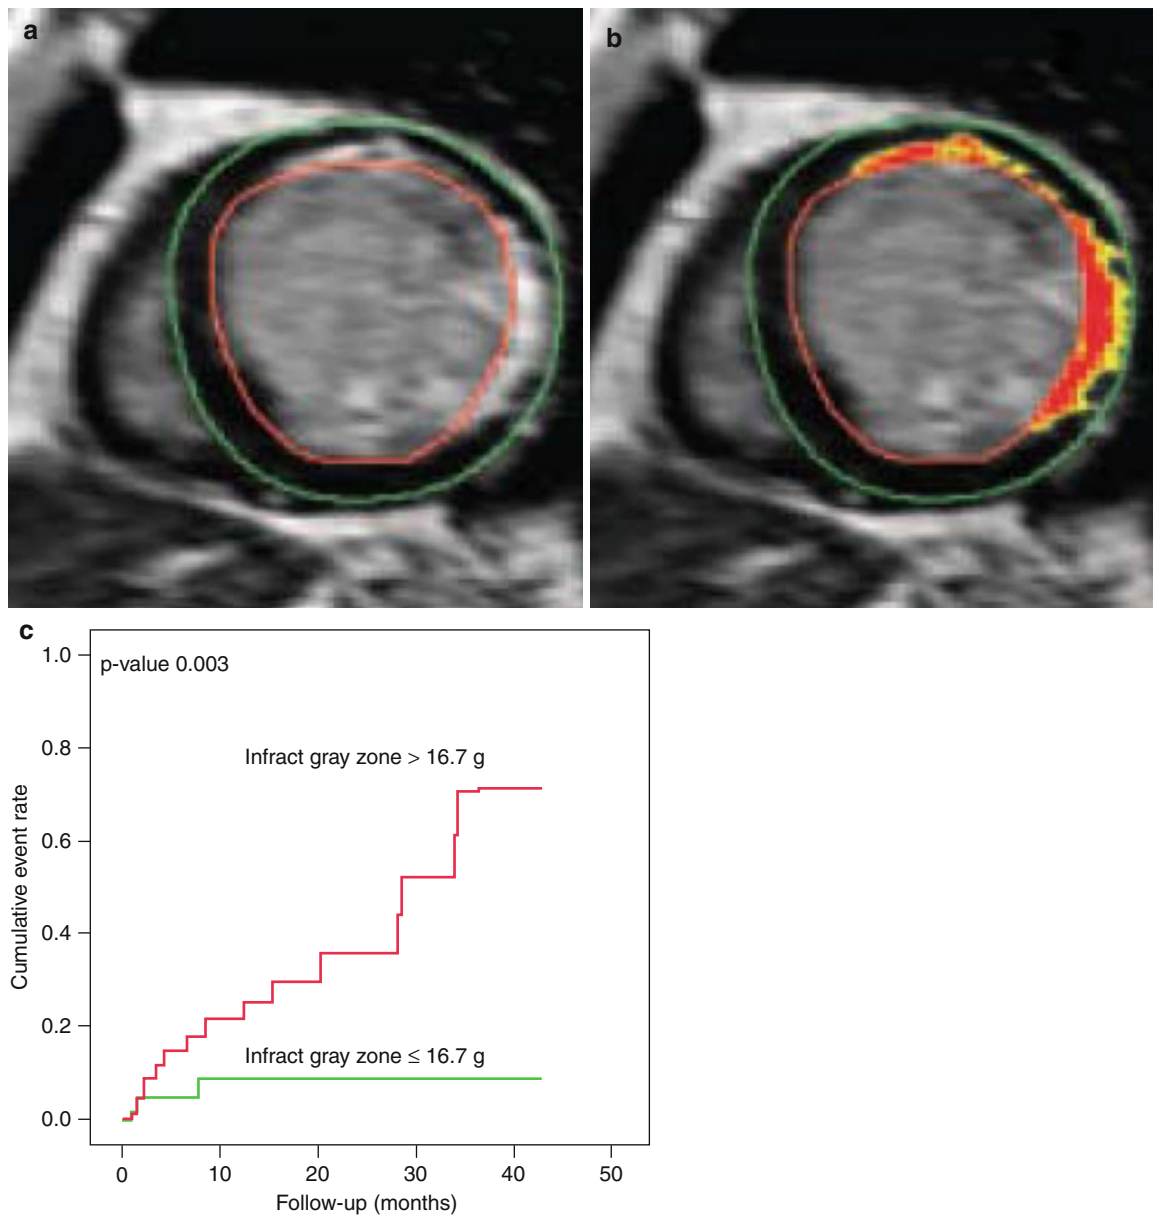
Assessment of the infarct gray zone. From a short-axis contrast-enhanced MRI image of a patient with a previous MI, the endocardial (*red*) and epicardial (*green*) borders are outlined manually (a). Subsequently, the maximum signal intensity within the infarct region is determined and the infarct core is defined as myocardium with signal intensity $\geq 50\%$ of the maximum signal intensity (*red area*) whereas
